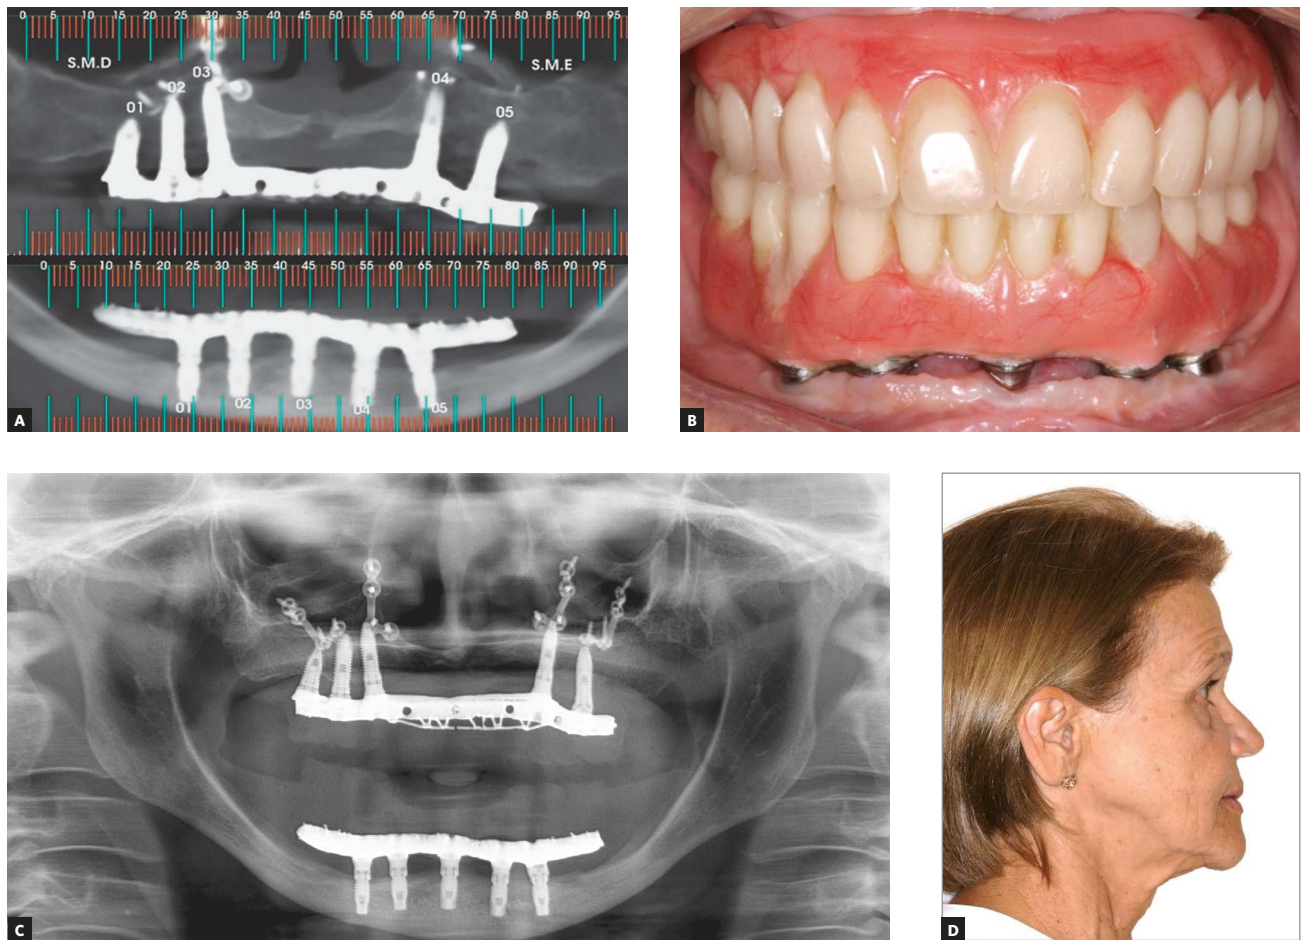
Postoperative images: A) cone-beam computed tomography after rehabilitation on five implants in the maxilla and five implants in the mandible; B) definitive dentures in place; C) panoramic radiograph at three-year follow-up; D) lateral view three years after implant-supported rehabilitation.
